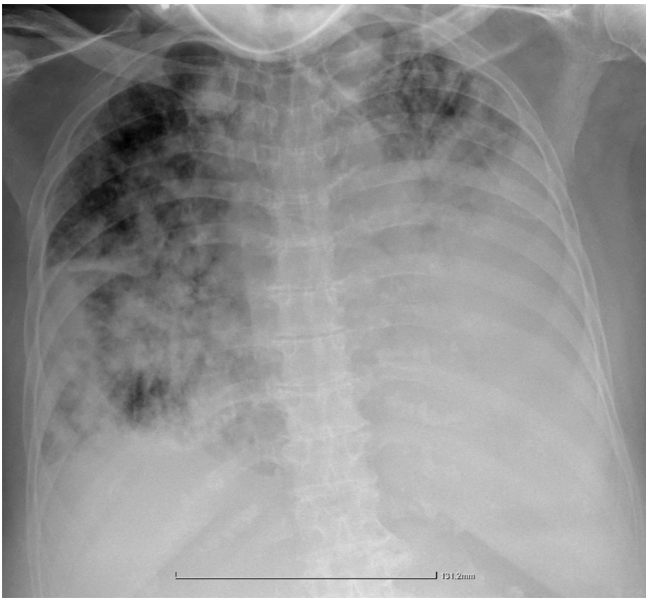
Last Chest X-ray in the ICU(intensive care unit). Extensive left pleural effusion filling the lung with confluent right lung opacities.
